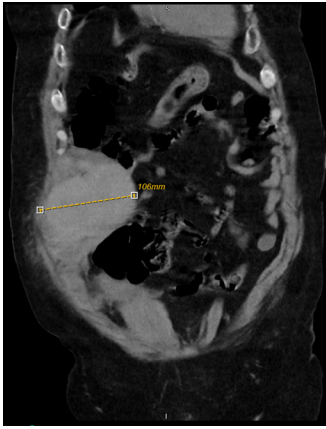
Anteroposterior CT scan coronal view, slice 19/63.
